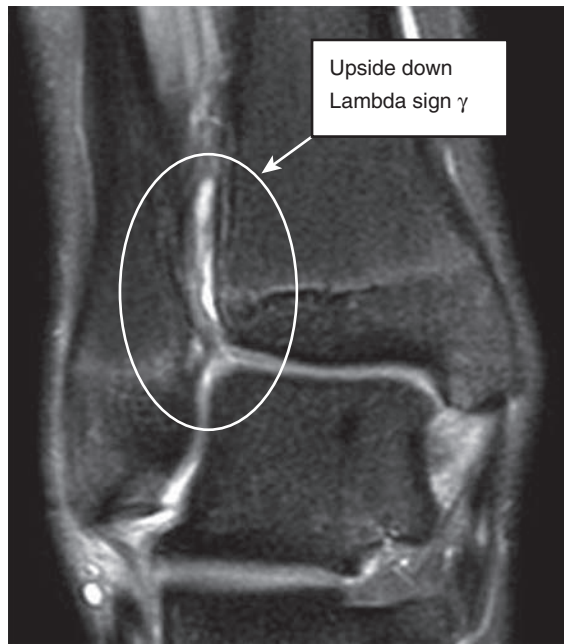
Example of a magnetic resonance image with lambda sign indicative of latent syndesmotic injury. (Courtesy Thomas O. Clanton, MD)
